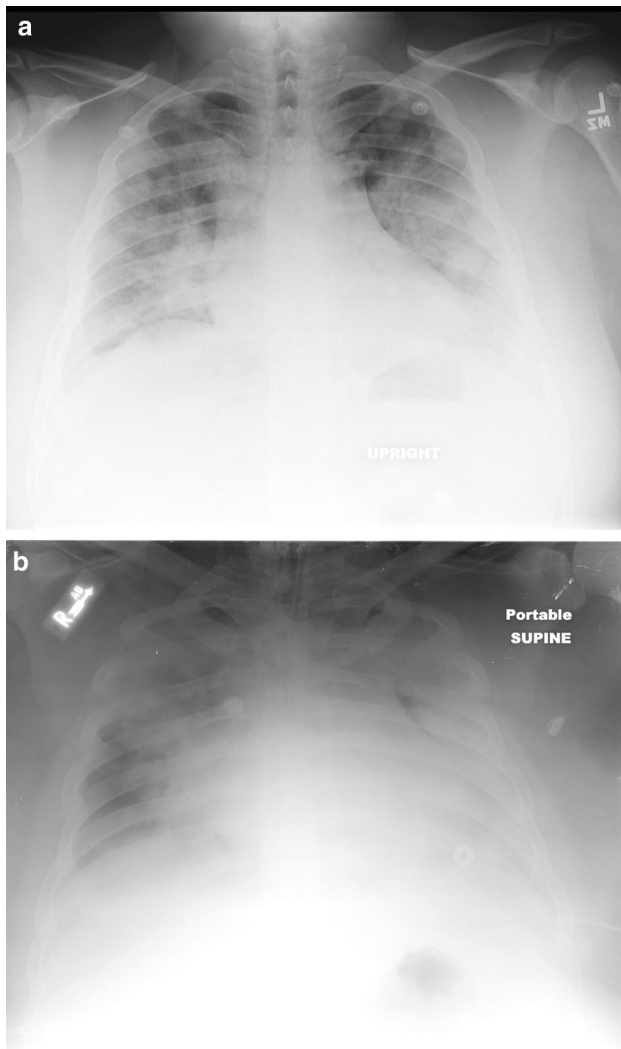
A 34-year-old male with H1N1 influenza with rapid progression of disease. a Chest radiograph on the day of admission shows bilateral, symmetric ground glass and consolidation with (b) rapid progression of bilateral pulmonary opacities on hospital day 3. The patient ultimately required intubation and ICU admission
